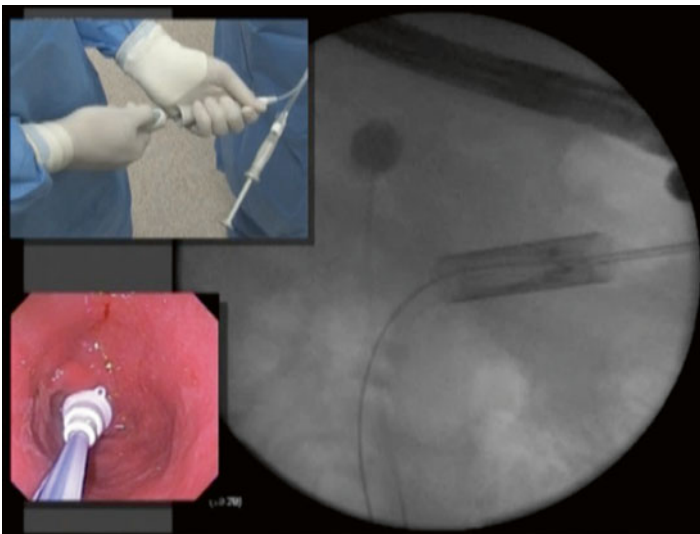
Ball with the sleeve being extended into duodenum and proximal jejunum up to 60 cm with X-ray guidance
